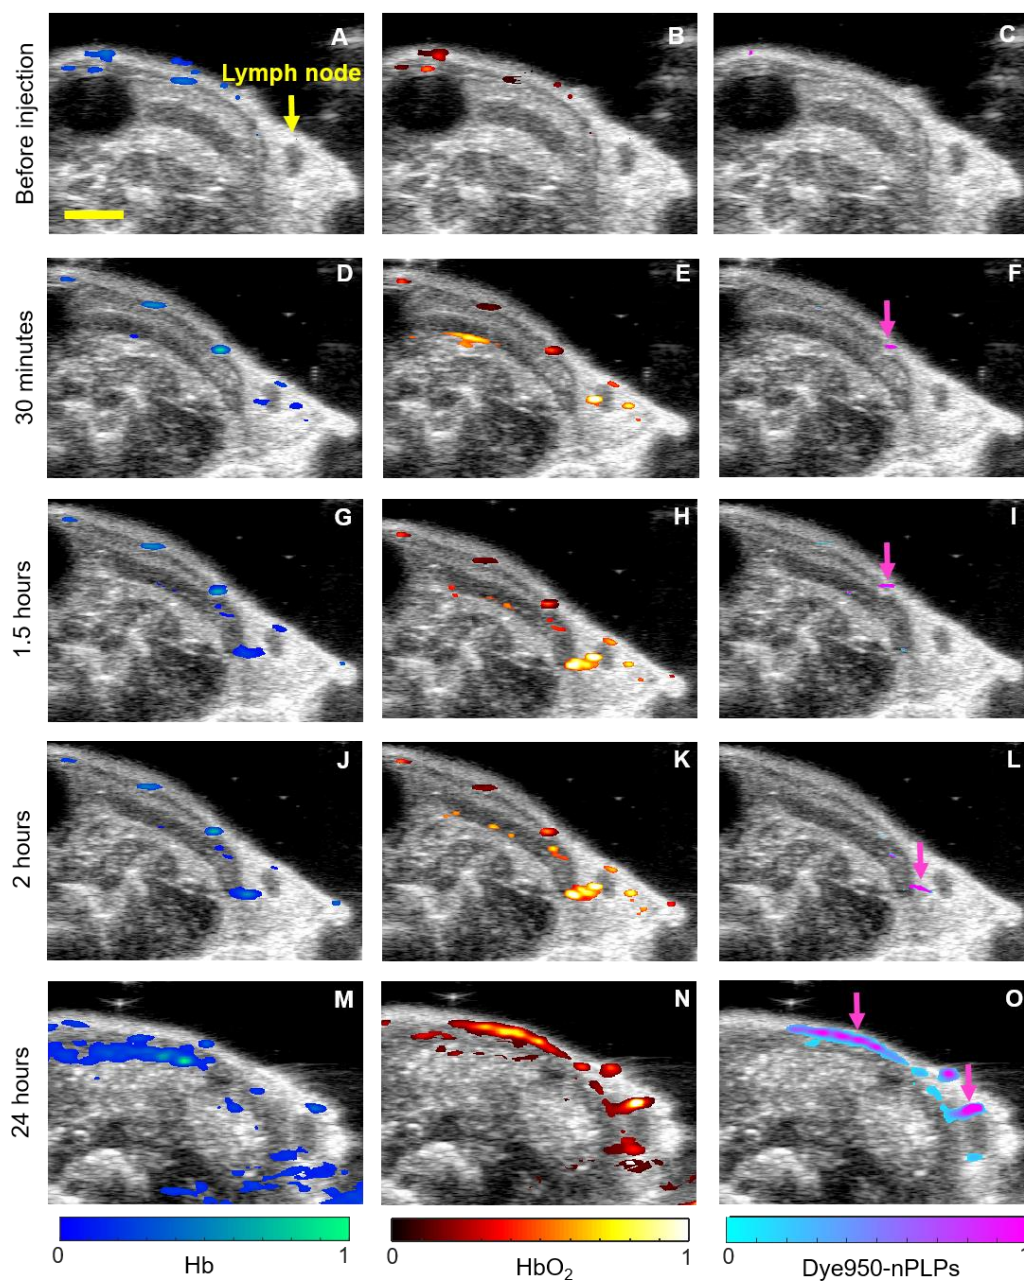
In vivo* US/PA imaging of Dye950-nPLP trafficking to the lymph node. Ultrasound (grayscale) and PA (color scale) overlay images after spectroscopic analysis to distinguish Hb, HbO<sub>2</sub>, and Dye950-nPLPs (columns left to right). Maps of absorber distribution before injection (A – C), 30 minutes (D – F), 1.5 hours (G – I), 2 hours (J – L), and 24 hours (M – O) after injection. PLPs were detected near the lymph node by 2 hours post-injection (L) and more substantial accumulation was observed by 24 hours post-injection (O). Pink arrows point to particles. Scale bar = 3 mm.
